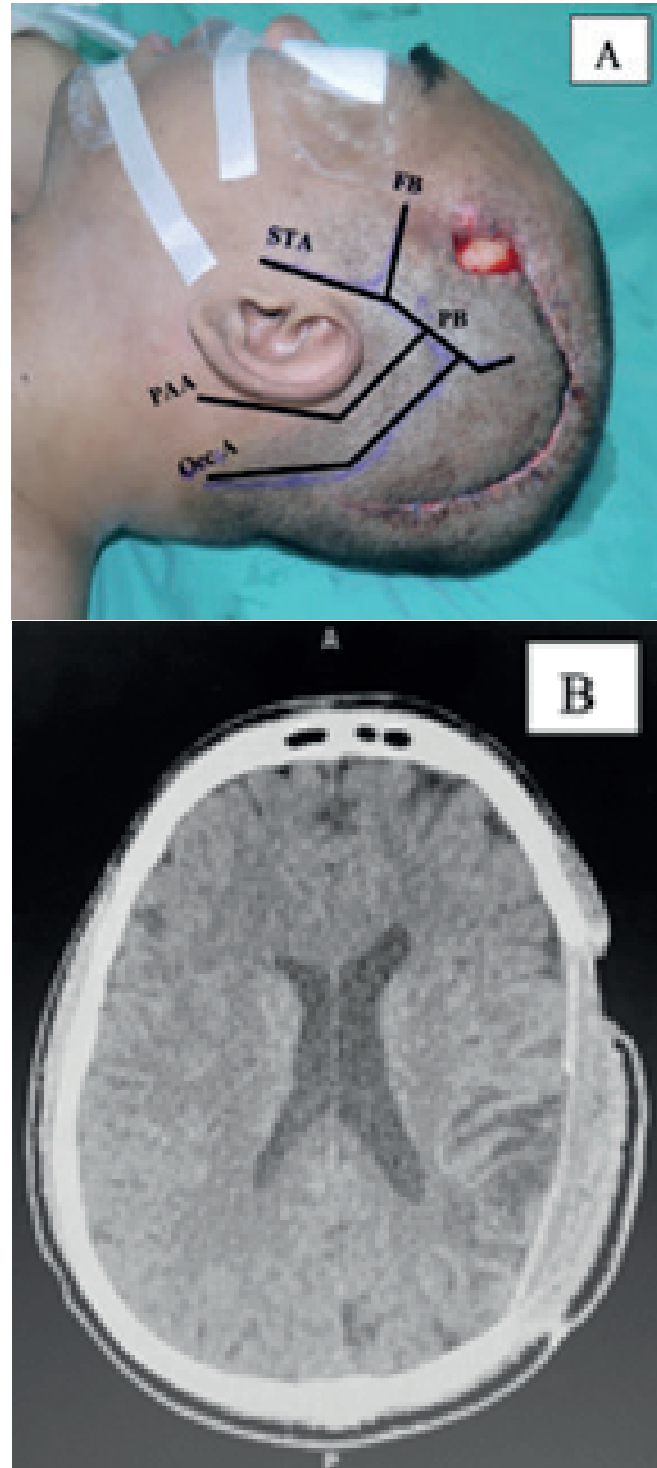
Pre-operative left fronto-temporal wound with exposed acrylic implant and previous craniectomy scar with Doppler guided marking of perforators. STA branches; frontal branch (FB), parietal branch (PB), posterior auricular artery (PAA) and occipital artery (Occ A) (A).
